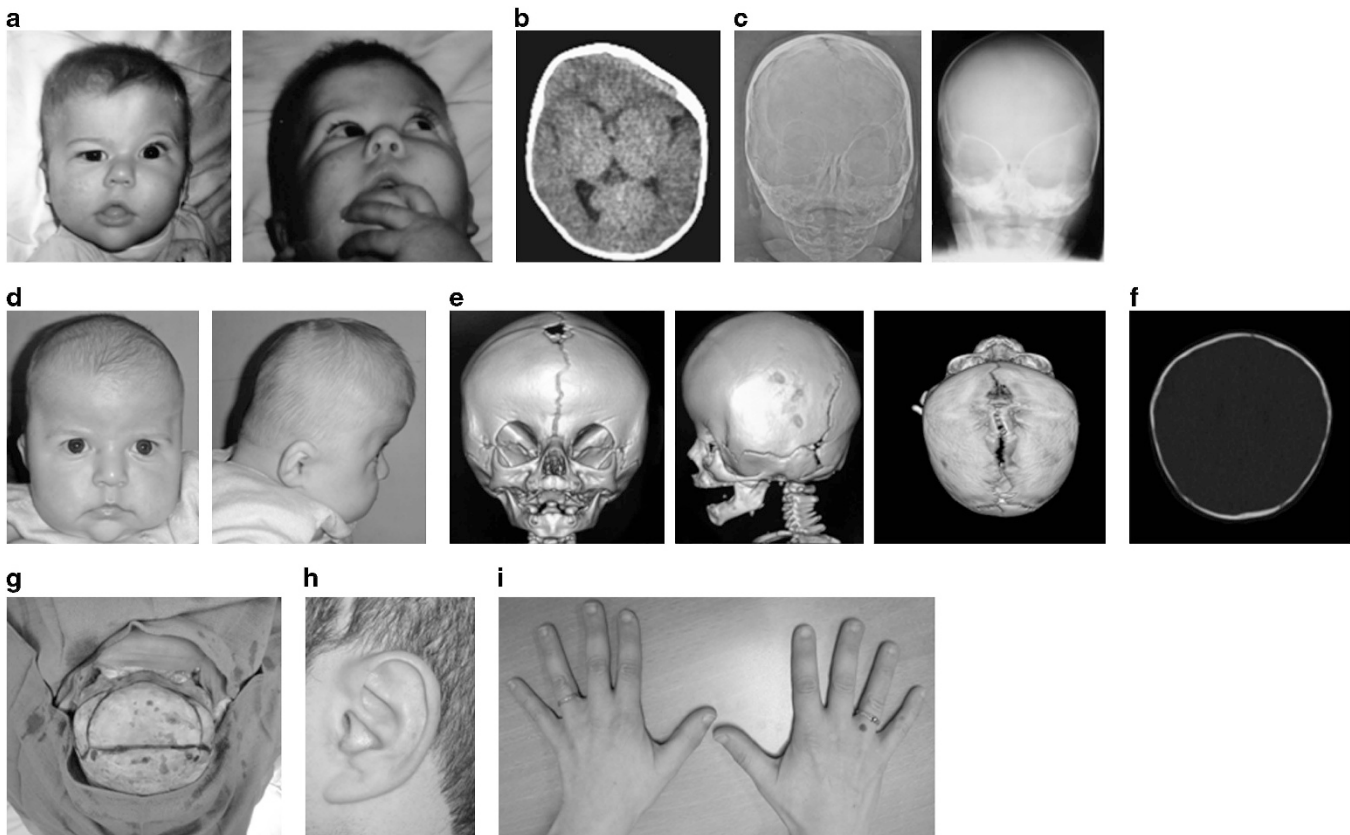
Clinical phenotypes. Family #1. Patient II-5 (a–c) at age 6 months. She presented with left plagiocephaly secondary to the early fusion of the left coronal suture: the two frontal photographs show unilateral coronal synostosis (a); computed tomography (CT) showing the left frontal deformation (b); posterior and anterior facial X-ray (c) with the characteristic harlequin's eye at the time of diagnosis (c-left) and at the time of surgery (c-right); note also the deviation of the sagittal suture. Family #1. Patient III-3 (d–g), son of II-5, at age 5 months. Frontal and lateral pictures showing bicoronal synostosis (d); 3D-CT showing the bilateral fusion of the coronal sutures (e); 2D CT image showing the fusion of the coronal sutures (f), intra-operative picture showing the deformation at surgery and the planned osteotomy lines in blue (g). Family #2, patient II-2. Small-sized ear with prominent crus (h). Family #4, patient II-2. brachydactyly (i). A full colour version of this figure is available at *The European Journal of Human Genetics* online.
